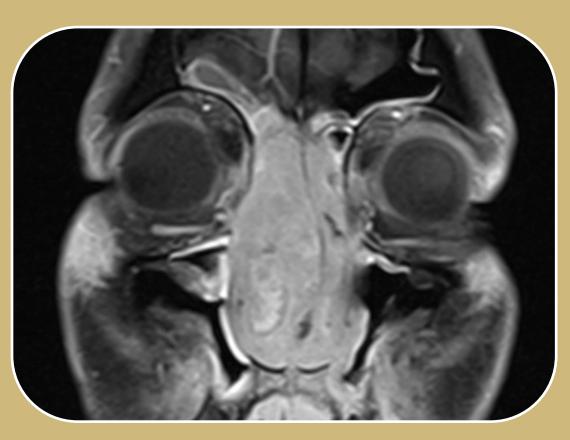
Axial (left) and coronal (right) T1 MRI with gadolinium obtained 1 month after initial CT
